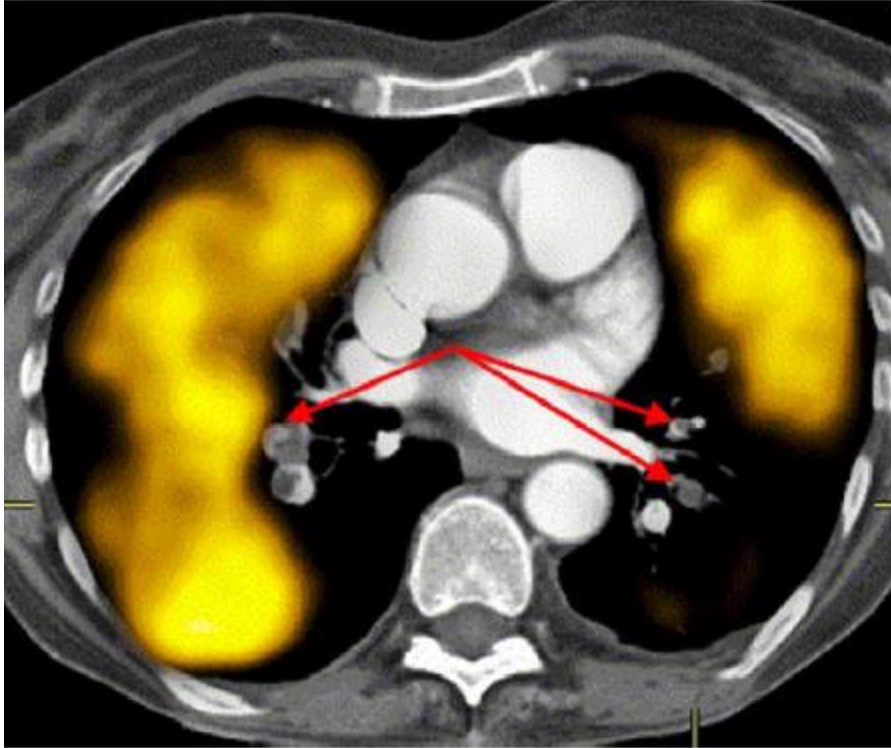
Fused perfusion SPECT and CTPA showing pulmonary emboli in bilateral arteries with the associated perfusion defects on SPECT. Image with permission 4.
